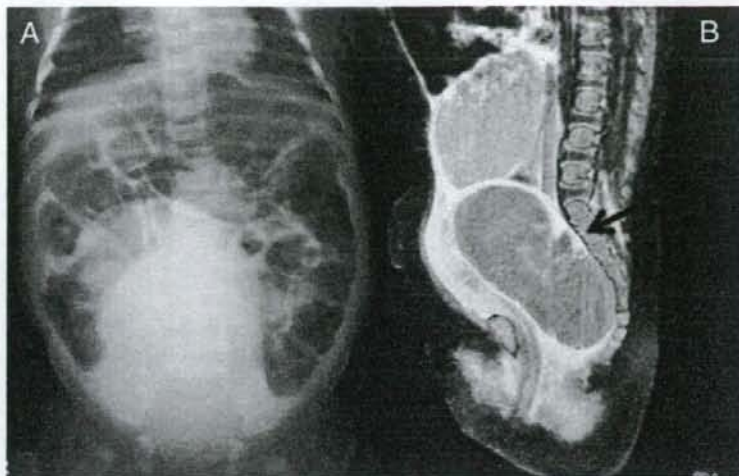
A, Abdominal radiography on admission. An opaque, hemispherical mass, which contains tumor as well as distended bladder, is apparent in the pelvic space with upward displacement of the intestines. B, Abdominal T1-weighted MRI after urinary catheterization. Tumor consisted of 2 cystic lesions. Fluid-fluid levels with different contrasts are clearly seen in this bilocular cystic mass. Fluid in the upper cystic lesion shows relatively high-signal intensity. Reticular structures suggesting the presence of fibrin (arrow) are observed in the lower cystic part.
